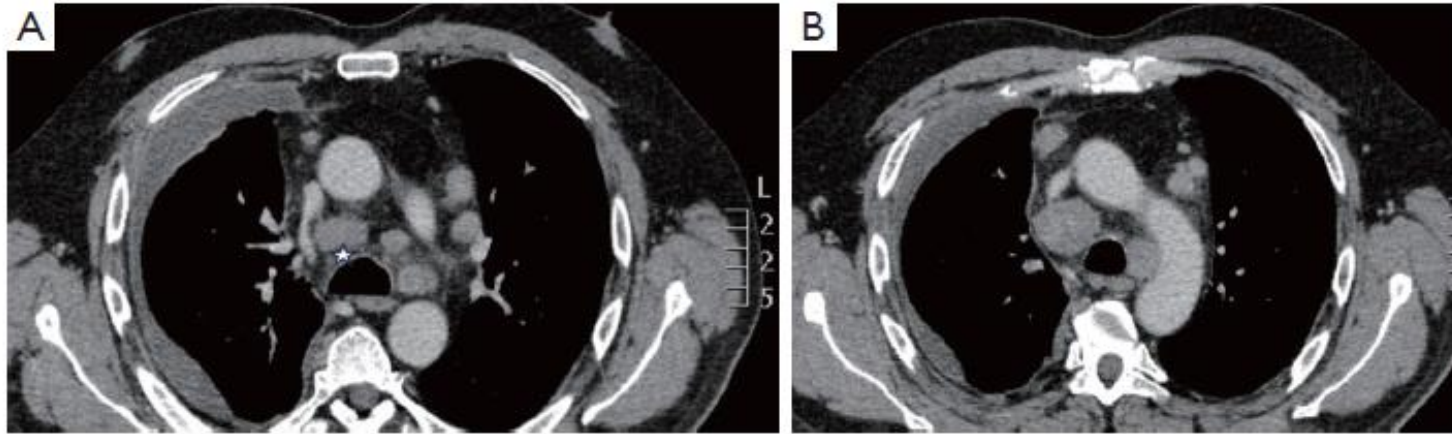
Thorax CT from different levels for the same patient. (A) Asterisk showing the space between 4R station and the tracheobronchial wall. (B) CT showing how the space between the 4R station and the right paratracheal wall decreases as we move down the trachea. CT, computed tomography.
